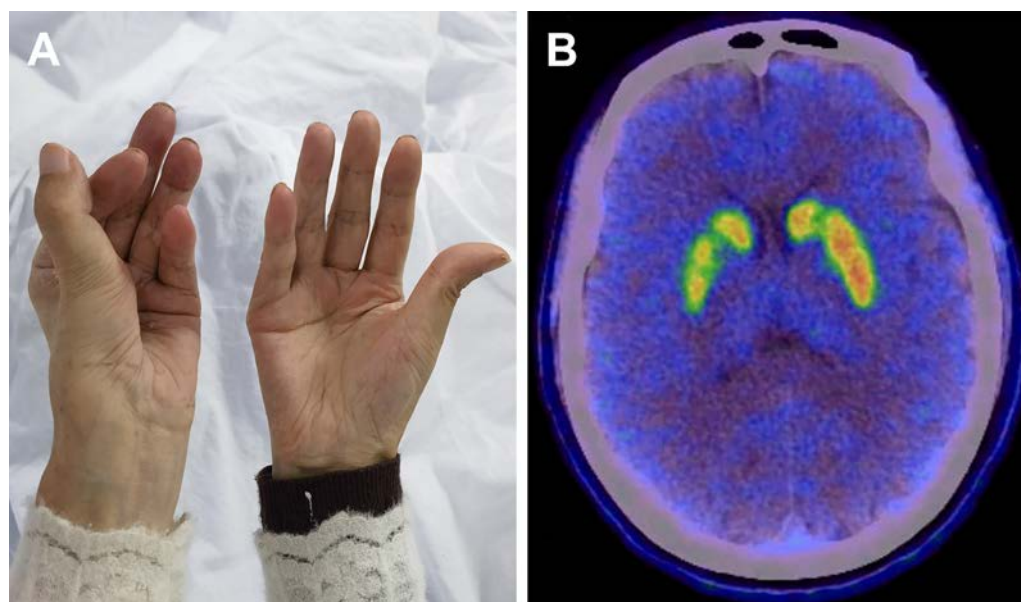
Striatal hand deformities in Parkinson disease. (A) Flexion of the left metacarpophalangeal joints, extension of the proximal interphalangeal joints, partial flexion of the distal interphalangeal joints, and flexion of the right metacarpophalangeal joints were observed. (B) ^{18}F -DOPA positron emission tomography/computed tomography showed reduced dopamine uptake in the bilateral striatum, which was more pronounced on the right. ^{18}F -DOPA, Fluorine-18-L-dihydroxyphenylalanine.
